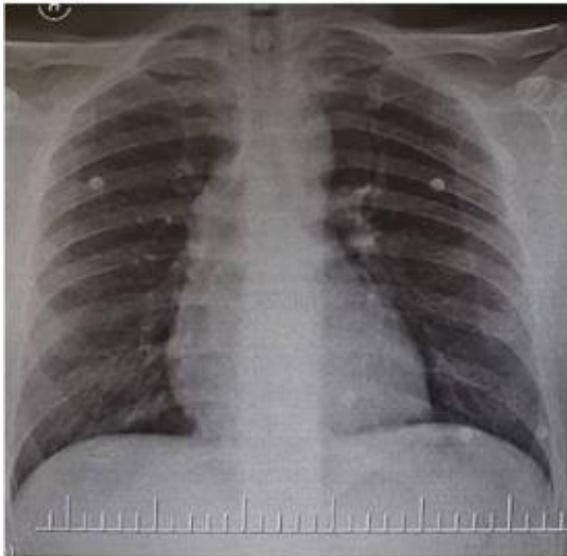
Chest radiograph on admission revealing enlarged mediastinum
